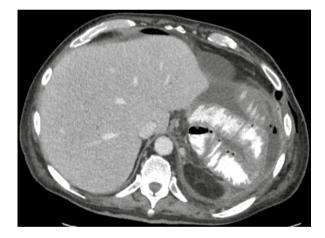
Computed tomography image of the abdomen after surgery. Status post total gastrectomy
